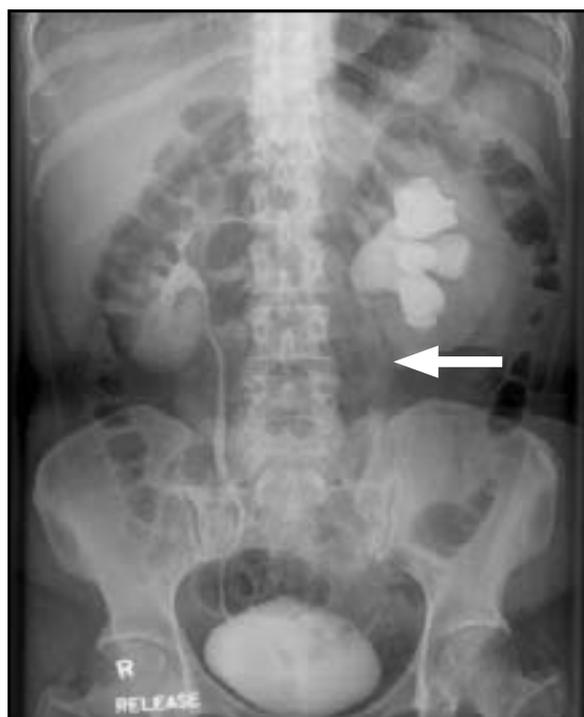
The intravenous urogram had similar features to the magnetic resonance imaging examination. The proximal left ureteric tumour was noted as a filling defect in the examination (arrow).
